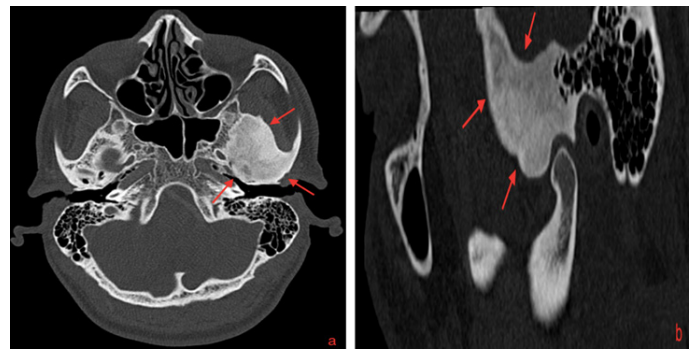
Axial (a) and sagittal (b) computed tomographic images of craniofacial fibrous dysplasia (red arrow) showing expansive mixed lesion with ground glass opacity involving temporal and sphenoid bones.
